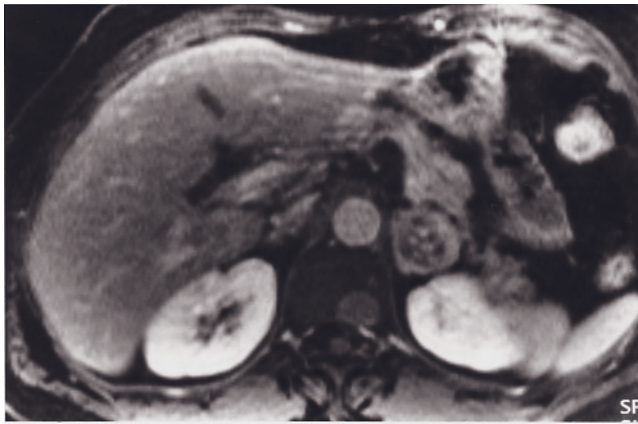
Adrenal adenoma with signal intensity drop and minor hemorrhage. T1-weighted GE (a), T1-weighted out-of-phase GE (b), T2-weighted fat-suppressed spin-echo (c), and immediate postgadolinium GE (d) images. Substantial signal intensity drop is present on the right adrenal adenoma comparing in-phase (a) to out-of-phase (b) GE images. Small high-signal-intensity foci are present on T1 (a)- and T2 (c)-weighted images, which is consistent with hemorrhage. The adenoma enhances intensely on the immediate postgadolinium GE image (d) and contains foci of diminished enhancement that correspond to punctate regions of hemorrhage. T1-weighted GE (e), T1-weighted fat-suppressed GE (f), T2-weighted fat-suppressed HASTE (g), immediate postgadolinium GE (h), and 2-min postgadolinium fat-suppressed GE (i) images in a second patient. A 3-cm left adrenal adenoma is present that contains foci of high signal intensity on the T1-weighted image (e), which do not suppress with fat suppression (f). The mass
